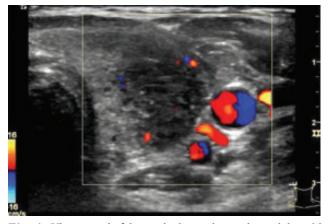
Ultrasound of the neck showed an enlarged thyroid gland with heterogenous echotexture. Both lobes had hypoechoic areas with ill-defined margins corresponding to the palpable hard regions. Colour flow Doppler showed reduced blood flow in both lobes. There were no definite nodules seen in the thyroid gland. A few cervical lymph nodes with normal morphology were seen.
